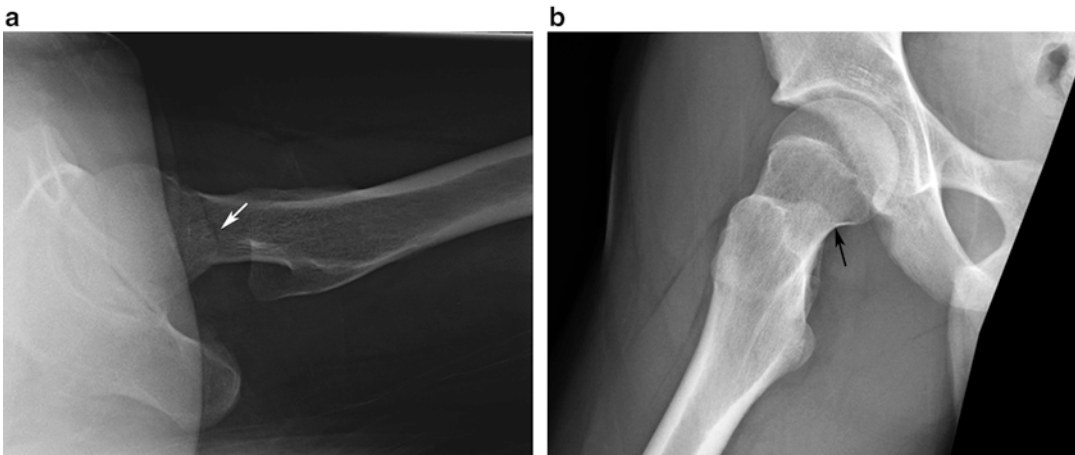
(a) Cross-table lateral radiograph of the left femur in a 15-year-old female s/p fall demonstrates a fracture through the femoral neck (*white arrow*). (b) Frog-leg lateral radiograph of the right hip in a 15-year-old male
